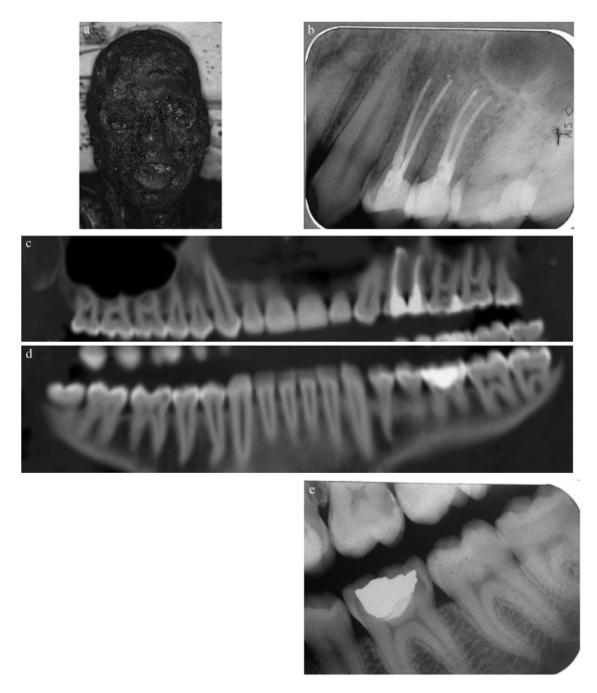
Case IRM 004. (a) A burned victim of a vehicle accident. (b) Antemortem upper left bitewing radiograph. (c) Postmortem upper jaw panoramic reconstruction. (d) Postmortem lower jaw panoramic reconstruction. (e) Antemortem lower left bitewing radiograph.
